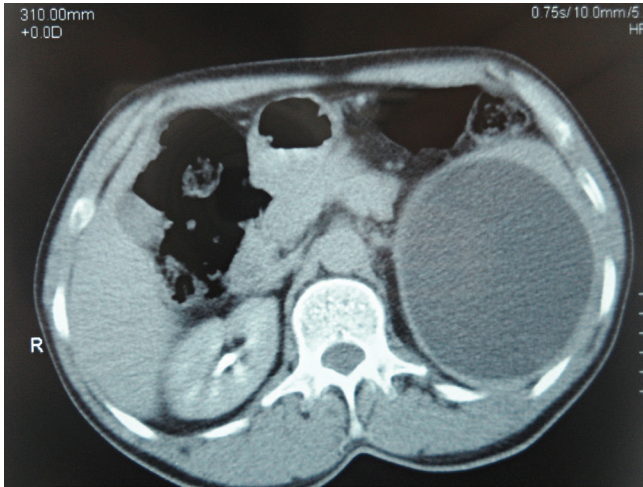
An abdominal CT scan reveals a 12 cm cystic mass originating from the spleen.
